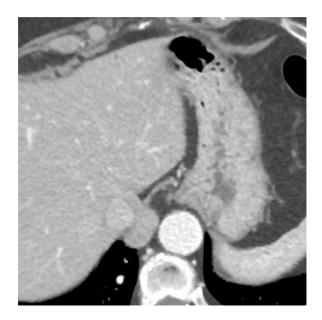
A circumscribed homogeneous soft tissue mass in the right para-mediastinal area in the lower middle mediastinum accidentally finding during a coronary computed tomography angiography (CCTA).
